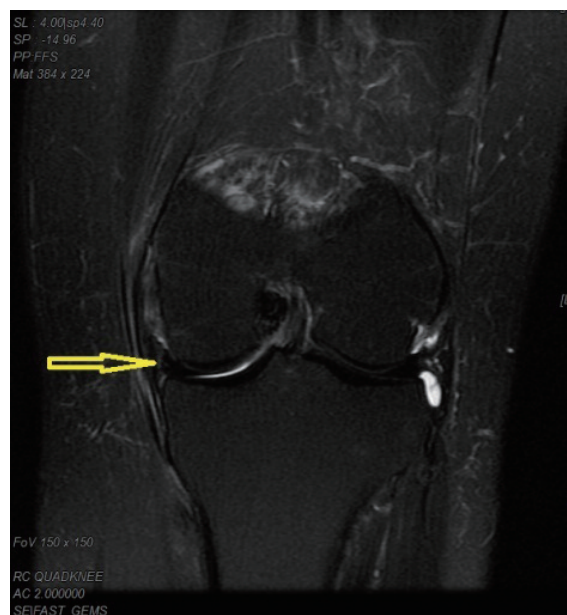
Left knee MRI from case 1 (2/9/2017)
